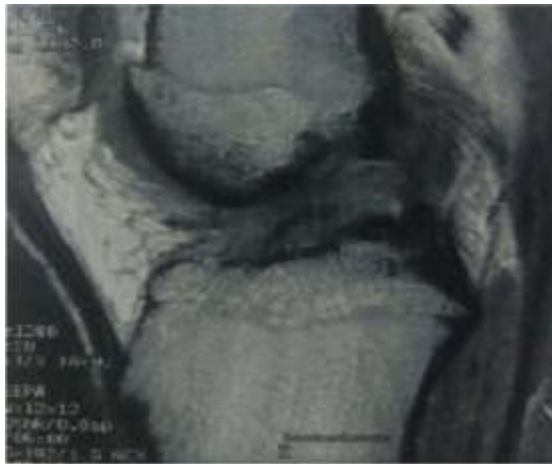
Partial tear of the anterior cruciate ligament. T1-weighted sagittal MRI image shows disrupted ACL fibers proximally compatible with an ACL tear.
